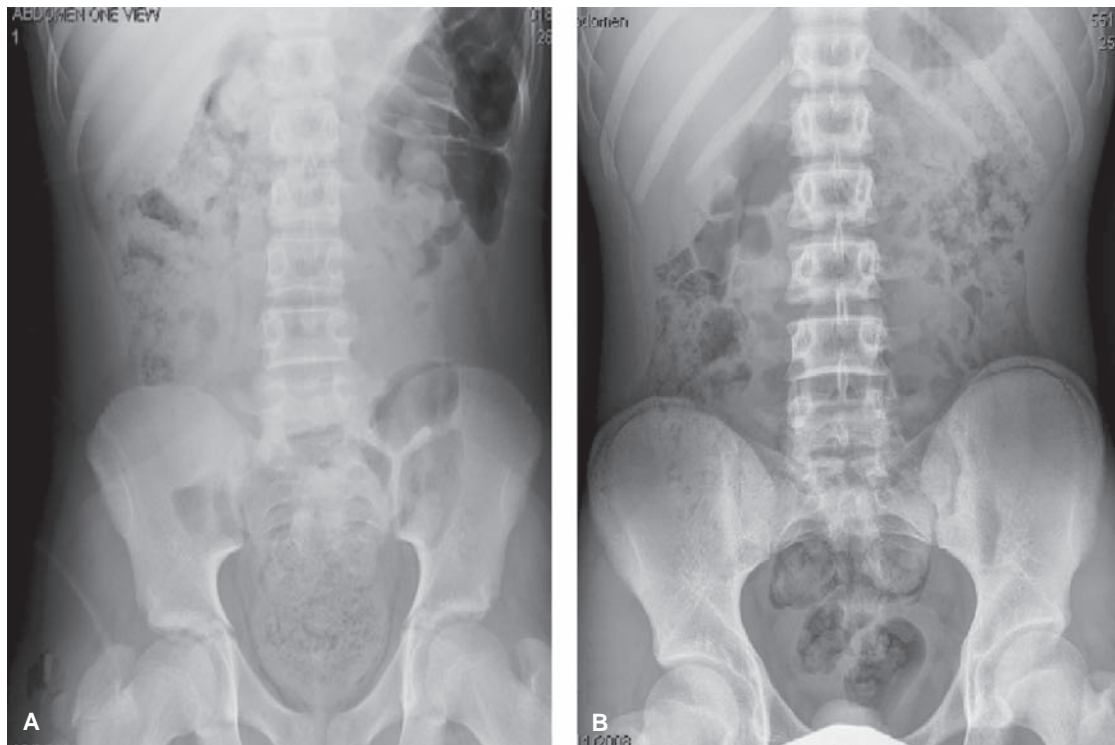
Both abdominal radiographs demonstrate evidence of constipation with extensive retained fecal material throughout the colon and rectum. The rectum in figure (A) is widened and contains a large fecal impaction while that in figure (B) is less widened and the stool is less compacted.
